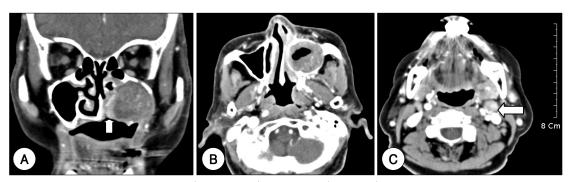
Radiology findings. A: Neck CT(coronal view). B: Neck CT(axial view) shows expansile mass in the left maxillary sinus. The mass has destroyed the hard palate partially(arrow), however, the posterior wall of the maxillary sinus is relatively intact. C: Neck CT(axial view) shows about a 1.3cm well enhancing lymph node on the left at level II.
